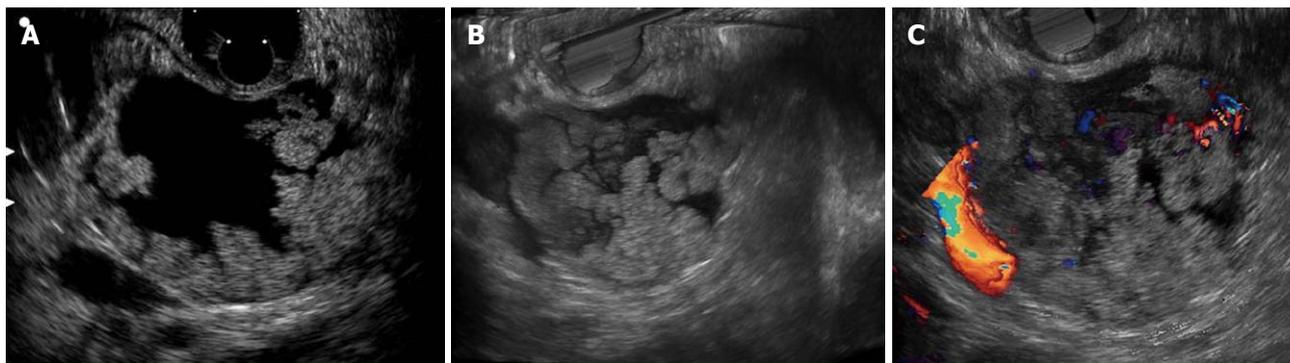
Image of a intraductal papillary mucinous neoplasm with high-grade dysplasia. A: There are numerous papillary growths in the intraductal papillary mucinous neoplasm (IPMN) maximum intensity projection image; B: The volume-rendering images reflect the surface architecture with reality; C: The combination of volume-rendering imaging and color Doppler imaging may be more useful in the diagnosis of the malignant potential of the IPMN.
